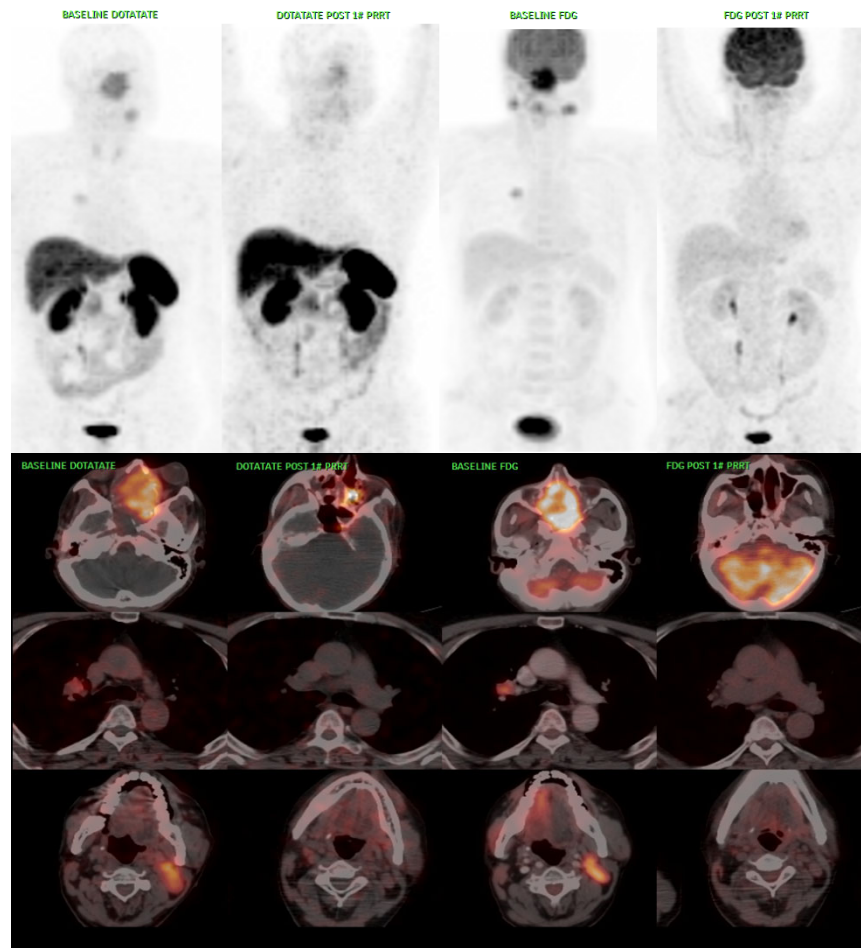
Comparative analysis of FDG and ^{68}Ga -DOTATATE PET-CT scans at baseline and post Chemo-PRRT. The patient presented with nasal obstruction, diagnosed as recurrent, high grade metastatic sinonasal NET, was referred for PRRT in view of inoperable metastatic disease. Maximum intensity projection (MIP) and transaxial views of ^{68}Ga -DOTATATE and FDG PET-CT scans at baseline and post Chemo-PRRT is shown above. Post-treatment PET-CT scans showed significant decrease in size and SSTR expression of primary sinonasaltumor (SUVmax 5.5 from 10.6) with complete metabolic resolution on FDG-PET/CT. Significant decrease in size and SSTR expression of left cervical level II lymph node (SUVmax 3.1 from 7.7) with complete metabolic resolution. Complete resolution of right hilar lymph node is evident from comparative analysis.
